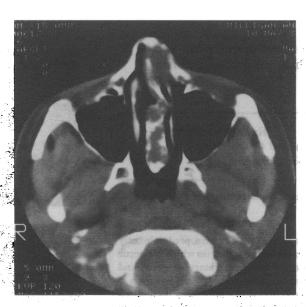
Axial CT scan showing expansion of the nasal septum
